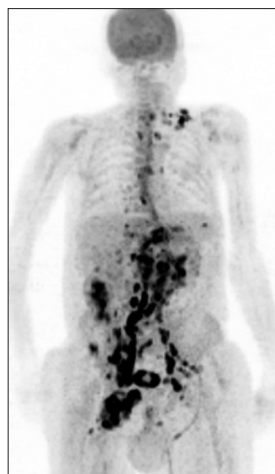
Fluorodeoxyglucose (FDG) PET MIP image showed that intense accumulation of FDG on inguinal lymph nodes and increased FDG uptake was detected on multiple lymphadenomegalies in abdomen-pelvis and the left-inferior jugular region, the left supraclavicular fossa and the mediastinal lymph nodes
